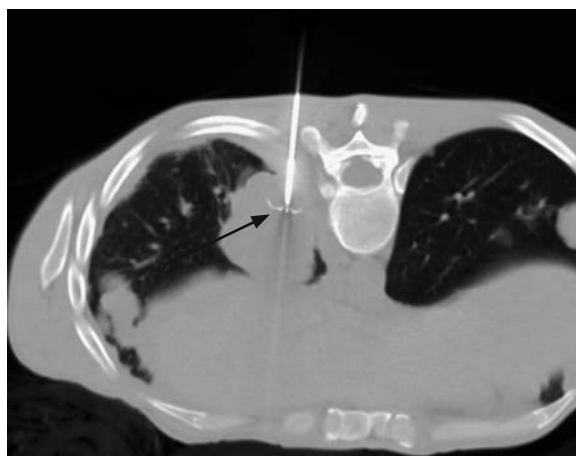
CT-guided RF ablation of an adenoid cystic carcinoma metastasis to the lung in a young man. Note umbrella array of RF probe tines that increases the volume of necrosis per burn (arrow)
